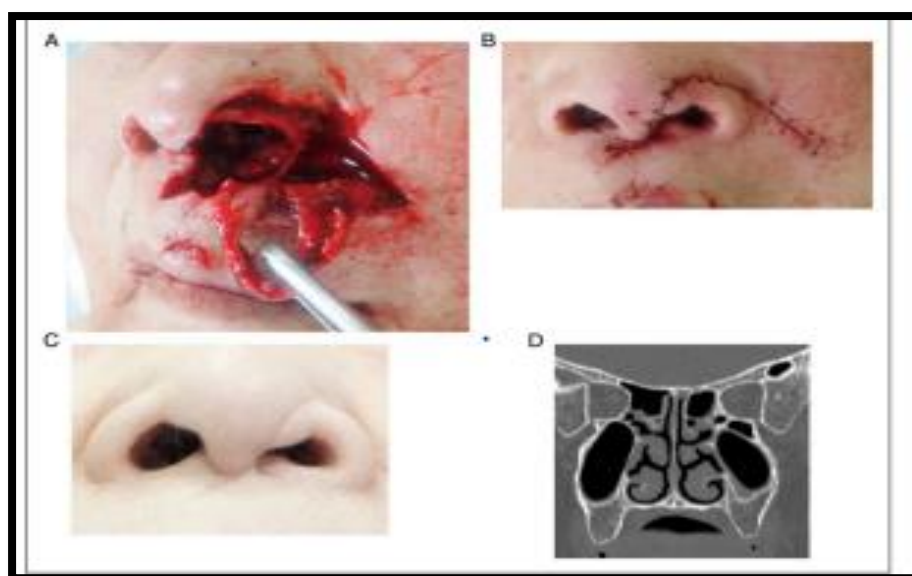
(A) Trauma to the nasal valve area at initial emergency department visit. A large laceration was observed in the nasal valve area and it was nearly detached. (B) Facial findings after suturing in the emergency department. (C) Facial findings at the first visit to the otolaryngology department. There is no sign of infection in the wound; however, there is a depression along the wound. (D) Paranasal sinus CT findings. No obvious sinusitis or nasal septal deviation was detected.
